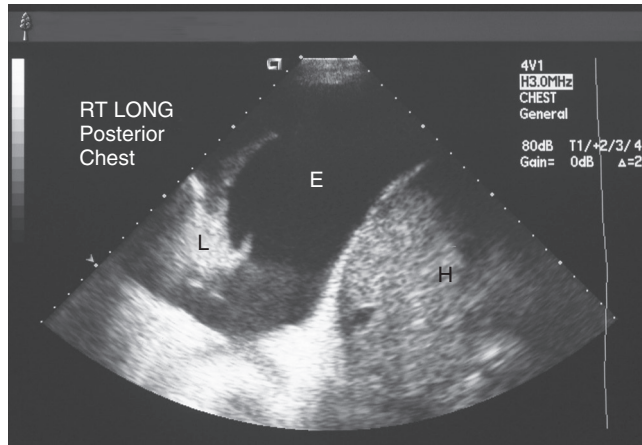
■ Ultrasound of right lateral chest to facilitate safe pleural access. E, Effusion; H, hepatic lobe; L, lung.
